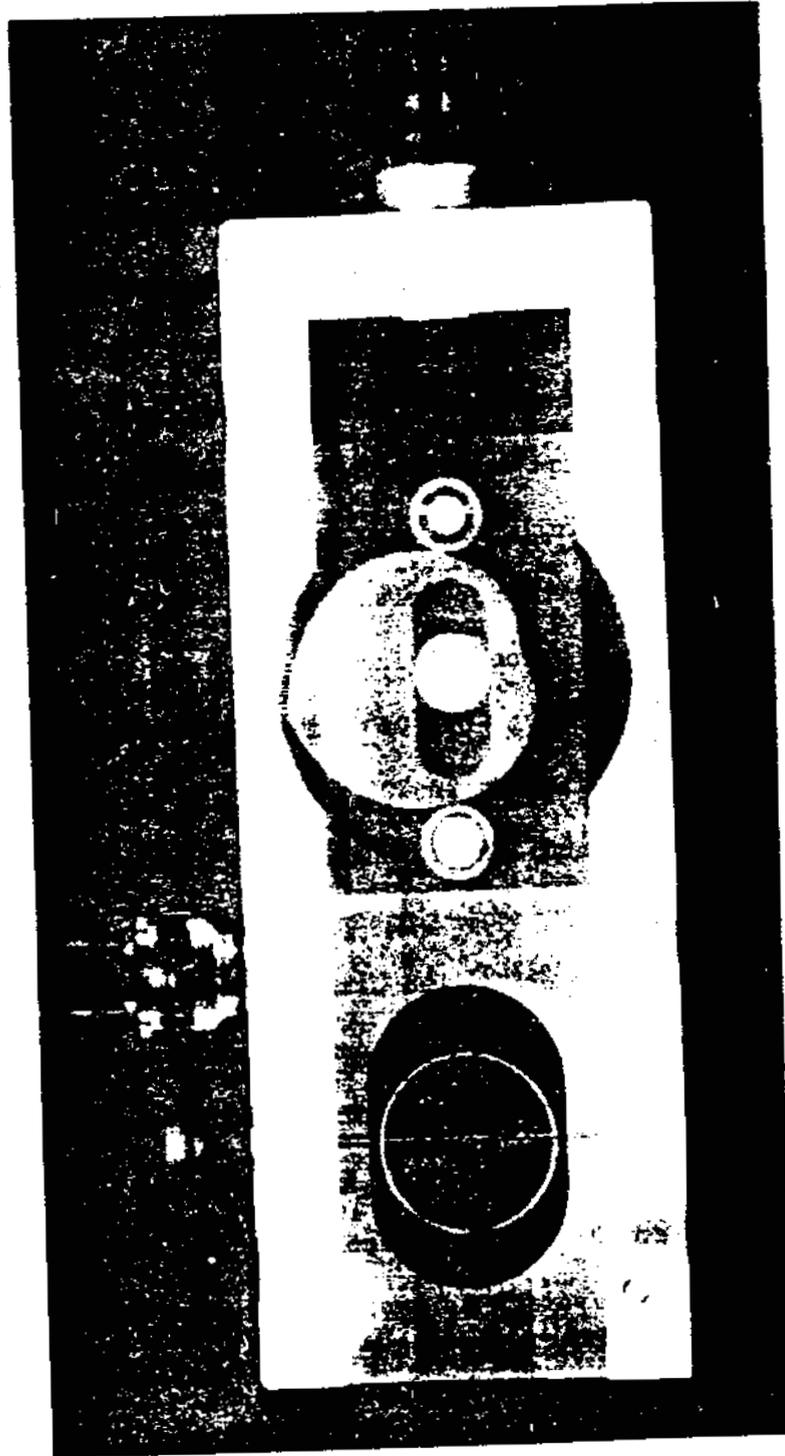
X-ray photograph of oscillating thermal precipitator showing drive mechanism.
